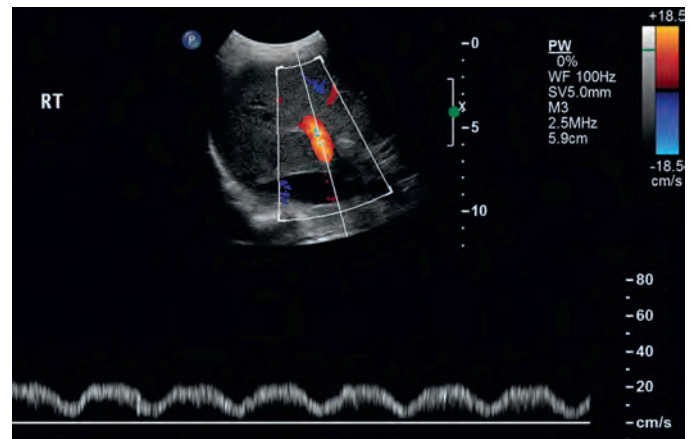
Color and pulsed-wave Doppler examination of the right portal vein showing normal flow.
